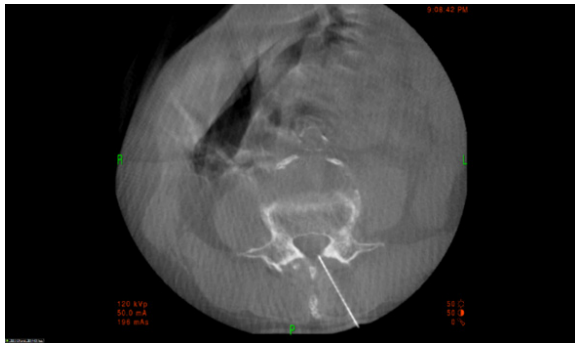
Needle position was confirmed using computed tomography (CT) image.
